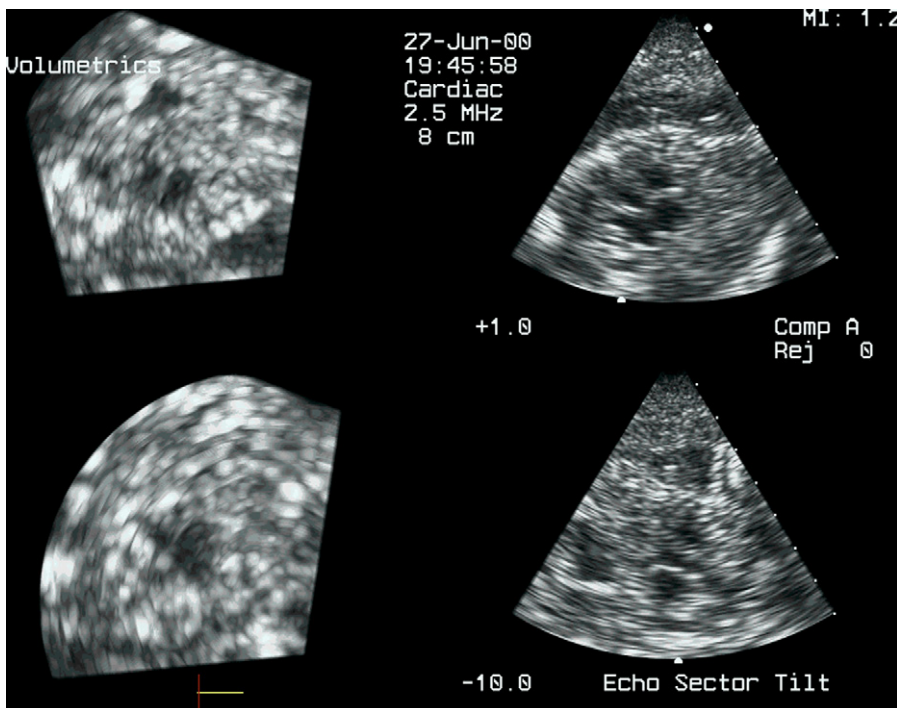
Real-time fetal 3D echocardiography using the first-generation 2D matrix array (Volumetrics, 2.5 MHz matrix transducer). Fetal echocardiography at 25 weeks' gestation shows the acquisition orientation (four-chamber view on the top right, a section perpendicular to it (through the aortic outflow) in the lower right and two perpendicular images from the elevation plane (cross sections through the two ventricles in short axis) (see also "4CH_25_vlm.avi" and the article by Tutschek et al (2000) [71]).
